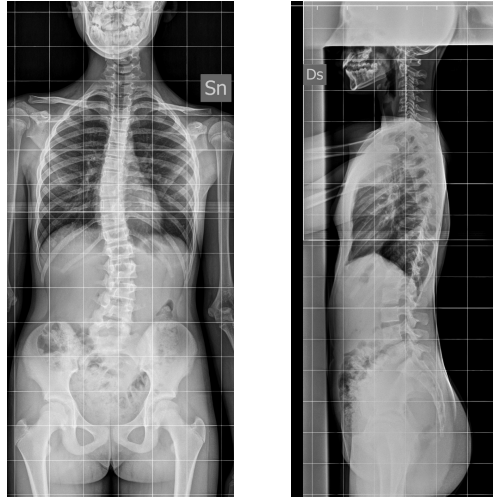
a: Spinal X-ray in a female patient with scoliosis (gold standard for diagnosis of spinal deformities).
